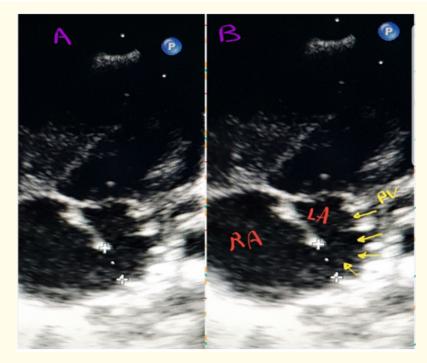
A and B Bidimensional transthoracic echocardiographic images from subcostal view demonstrate the superposterior ASD++ between the left shifted septum primum and the posterior atrial wall. LA: left atrium, RA: right atrium, Yellow Arrows: Pulmonary veins.
